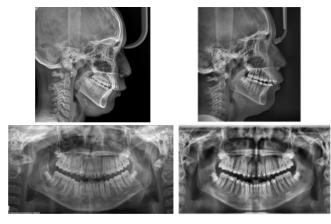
Comparative radiographic analysis
